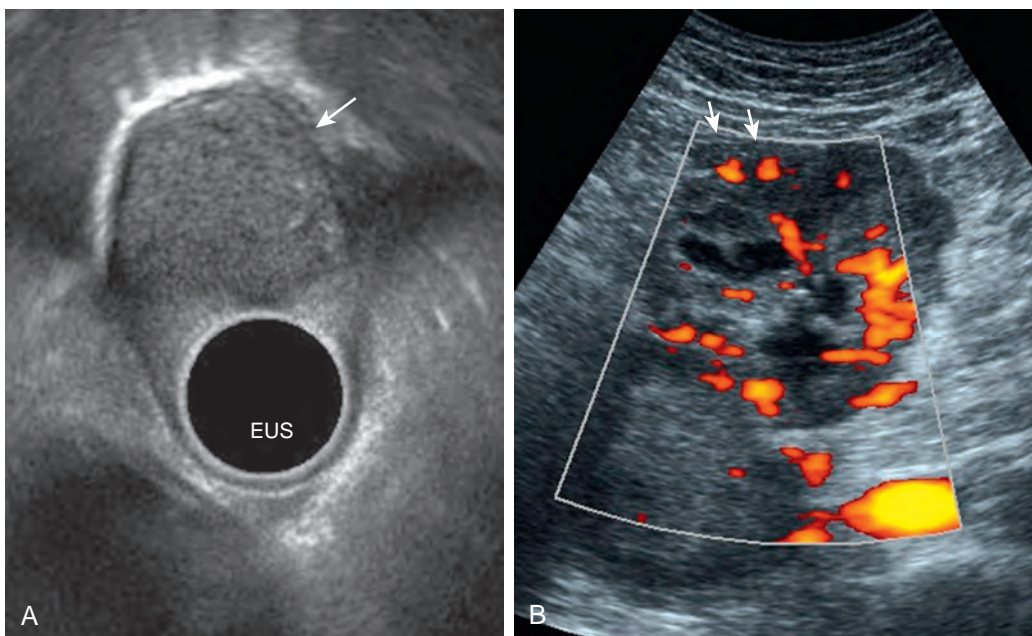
Focal masses. A. Distal esophageal polyp cancer with intact bowel signature (arrow). B. Bulky, intraperitoneal, dumbbell hypervascular GIST arising from small bowel (arrows). EUS, Endoscopic ultrasound.
